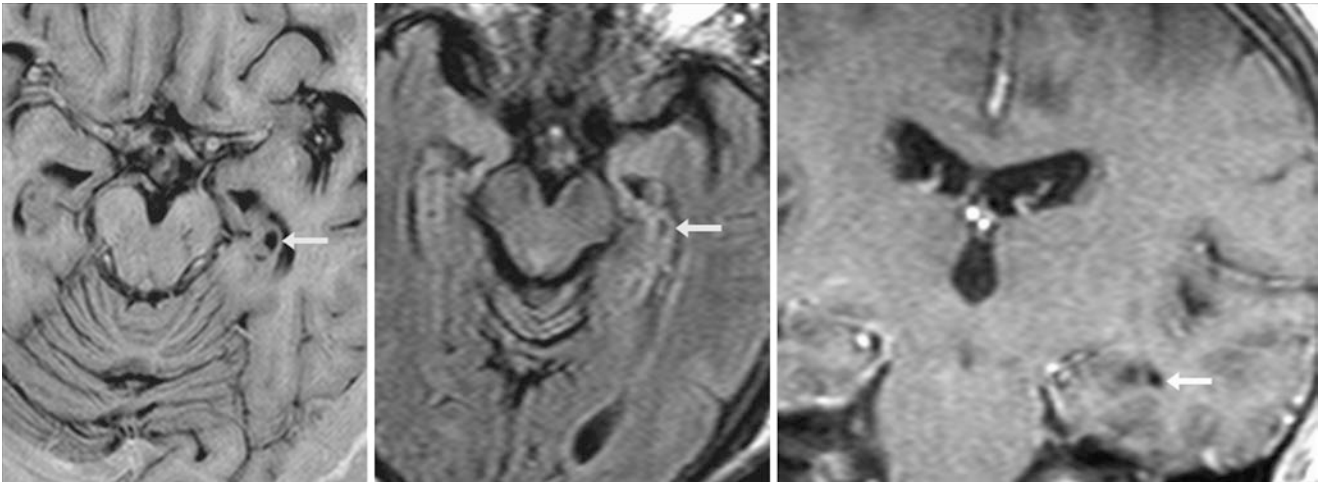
A 70 year old was tested with a 1.5 T MRI that showed a prominent left hippocampal cyst (*arrows*) on a 1-mm-thick axial T1 IR (*left*). The cyst suppresses like CSF on FLAIR (*middle*) and lacks enhancement on coronal postcontrast T1WI (*right*)
